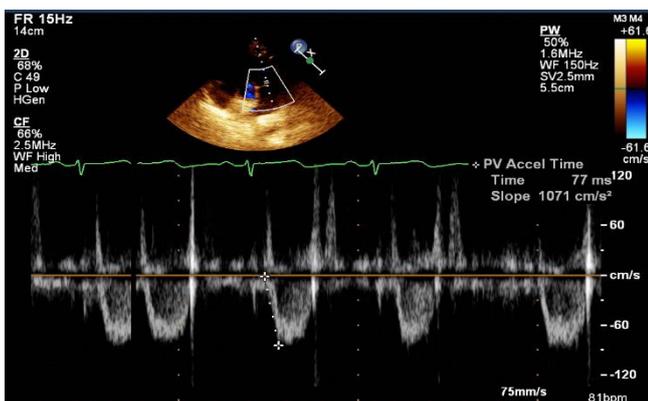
Pulse wave Doppler interrogation across the pulmonary valve showing the pulmonary acceleration time of 77 msec suggestive of severe pulmonary hypertension.
